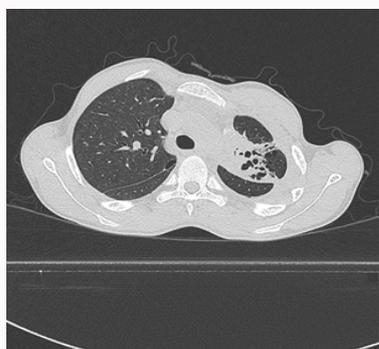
Images in a 19-year-old man with unknown exposure history who presented with fever and cough. Axial thin-section collimated unenhanced CT image shows apical consolidation with small cavitation phenomena with a "breadcrumb" appearance.
